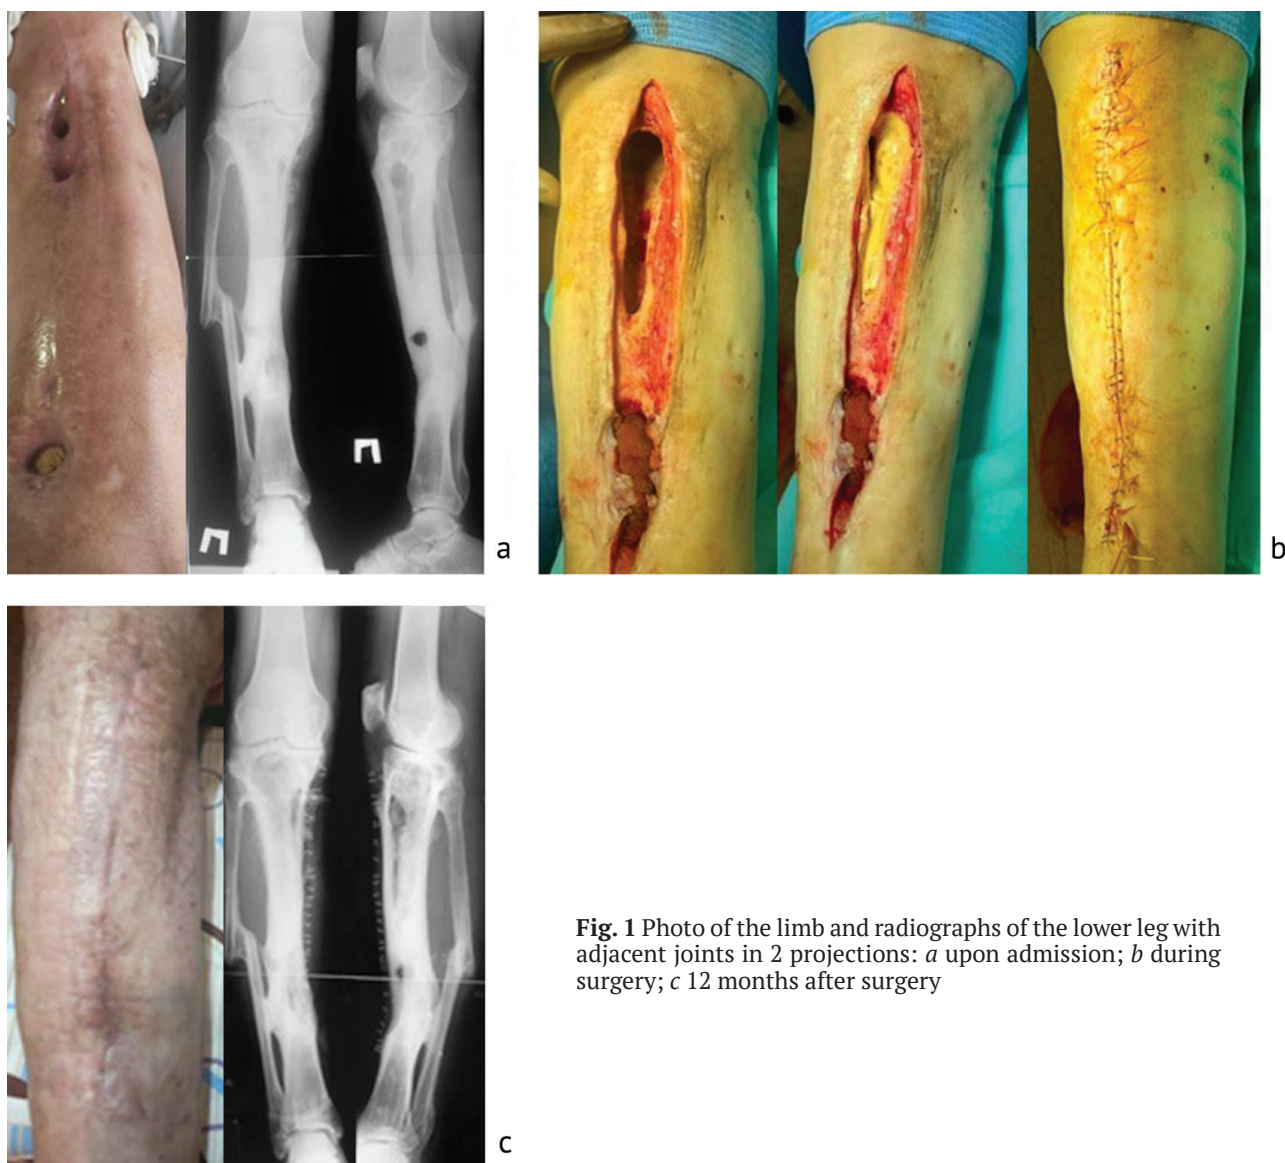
Photo of the limb and radiographs of the lower leg with adjacent joints in 2 projections: *a* upon admission; *b* during surgery; *c* 12 months after surgery
